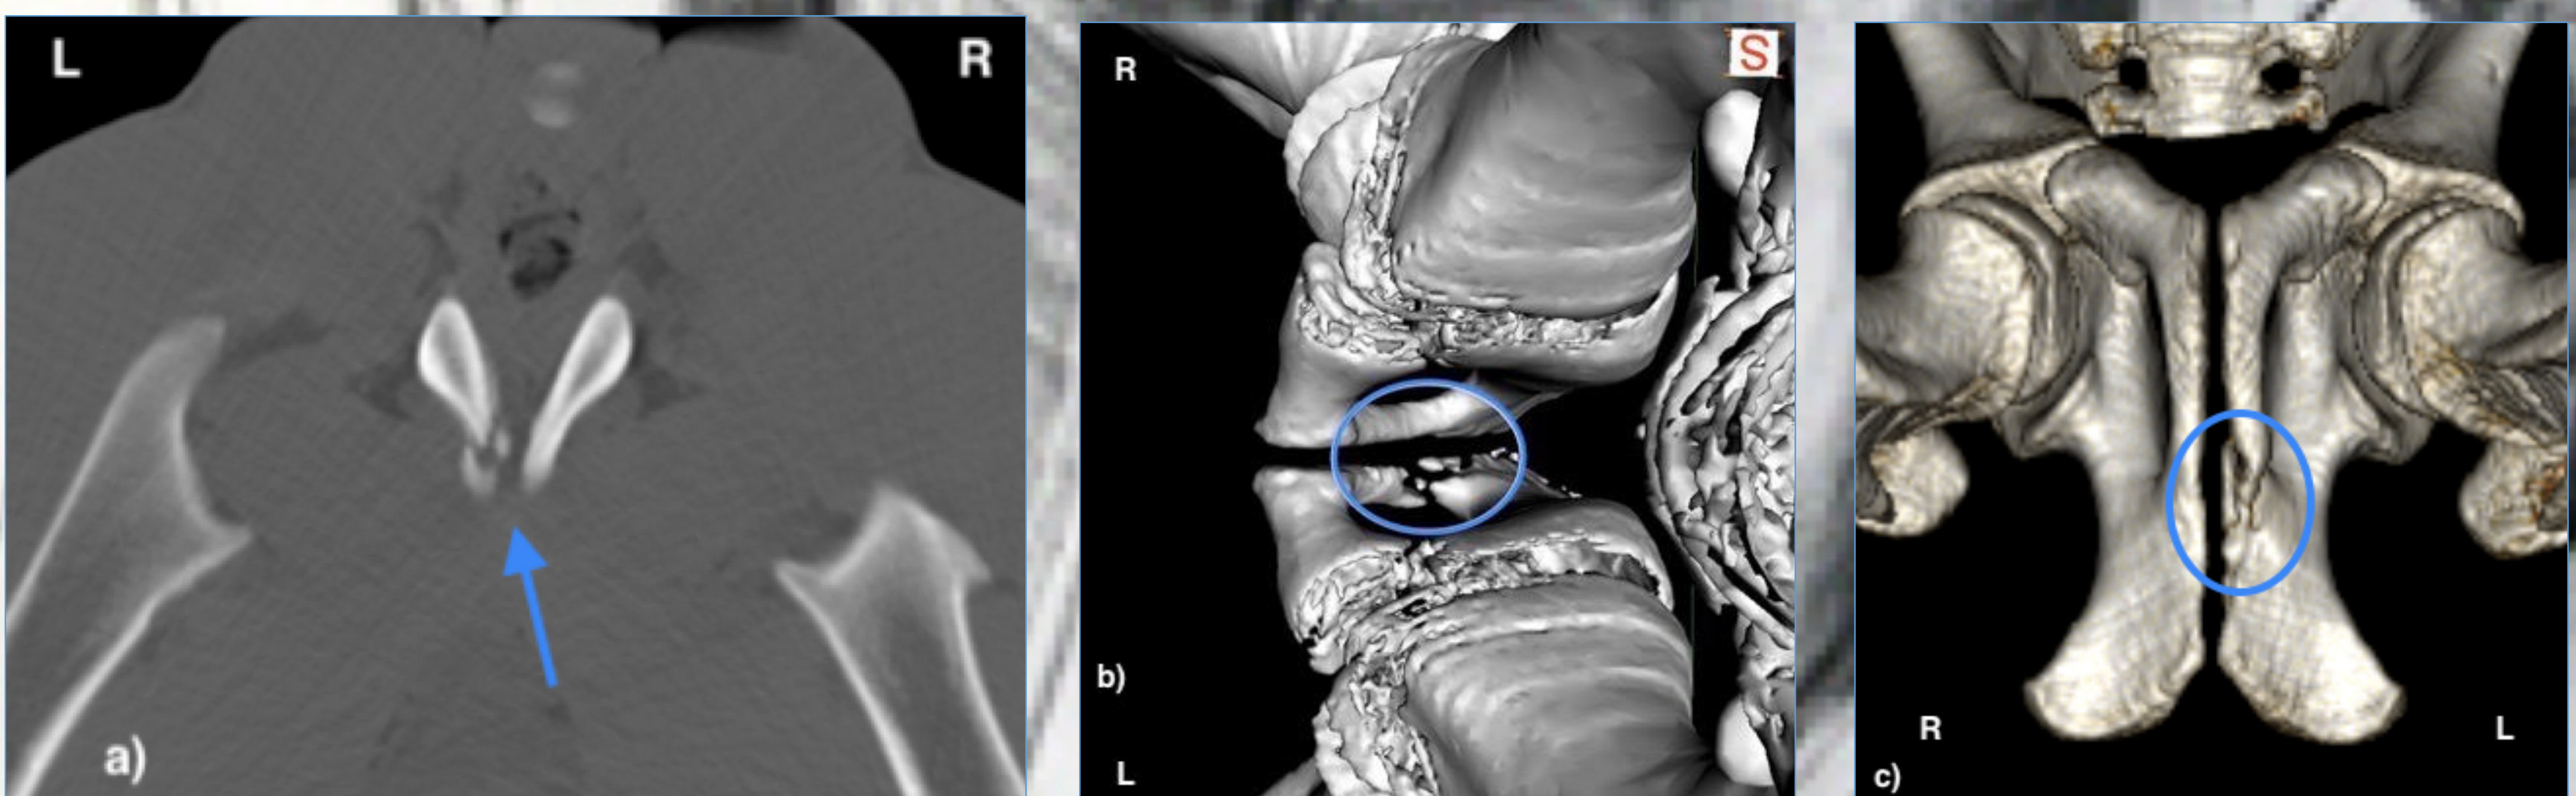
Transverse plane (a), surface rendering (b) and volume rendering (c) CT images of the pelvis showing bone fragmentation at the level of the caudal branch of the left pubis consistent with a slightly displaced fracture.
